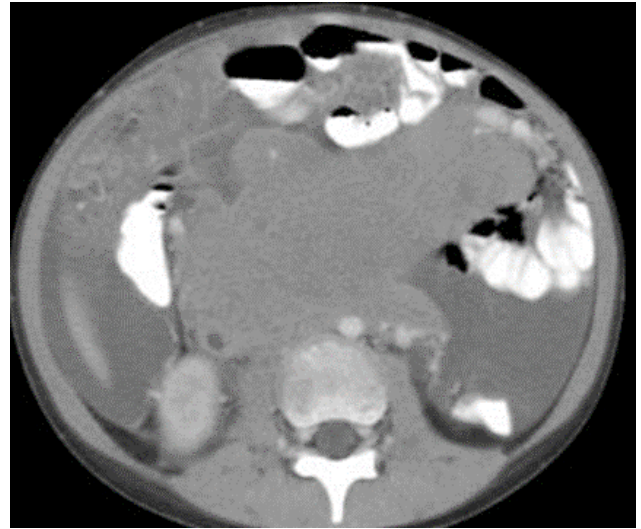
Repeat CT scan at the mid abdomen.
